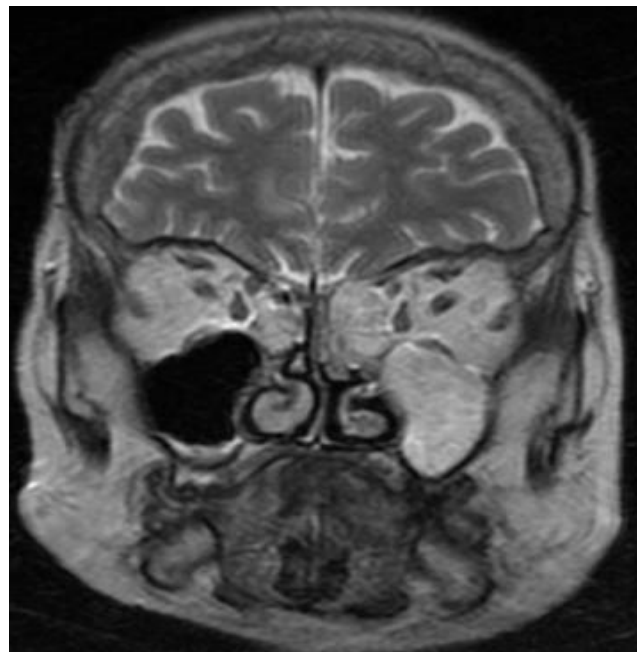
T2-weighted MRI brain and orbits coronal section shows hyperintense lesion involving left maxillary and bilateral ethmoidal sinuses.
